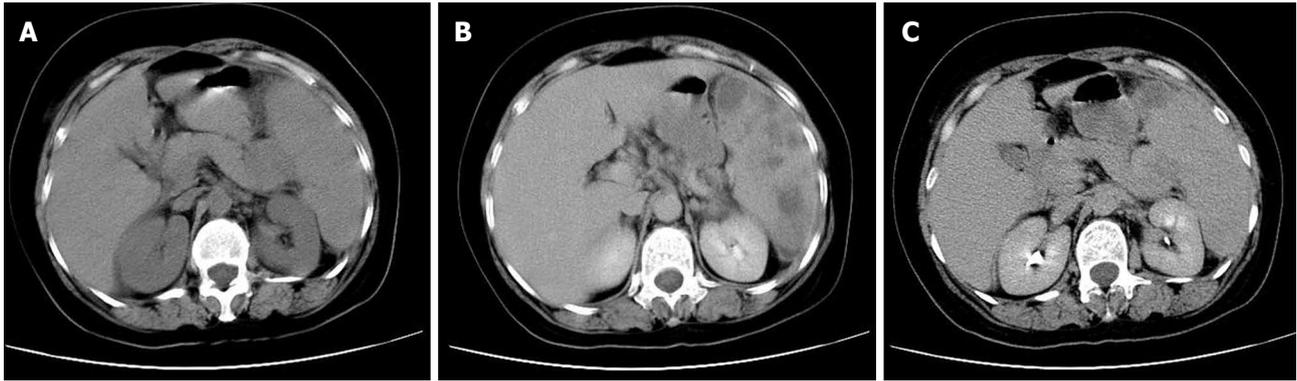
Computed tomography scan showing a low density mass at the pancreatic tail (A), splenomegaly and splenic infarction (B), and a mass at the pancreatic tail (C) in a patient with isolated pancreatic granulocytic sarcoma.
